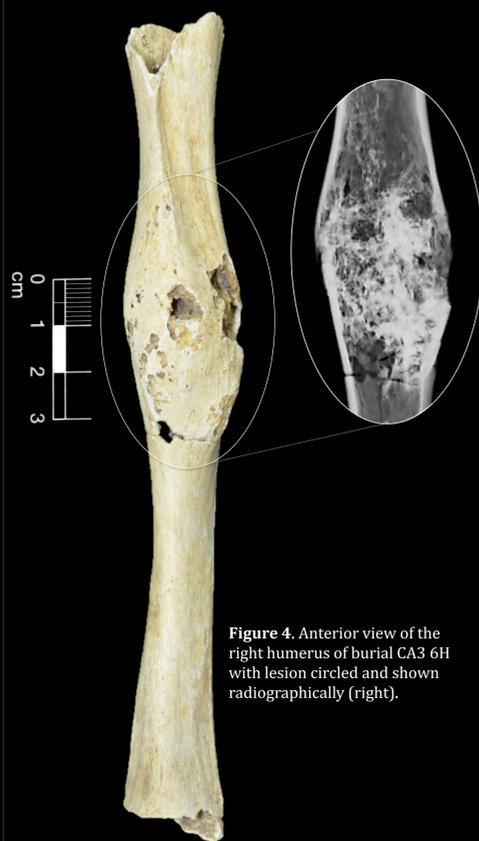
Anterior view of the right humerus of burial CA3 6H with lesion circled and shown radiographically (right).
